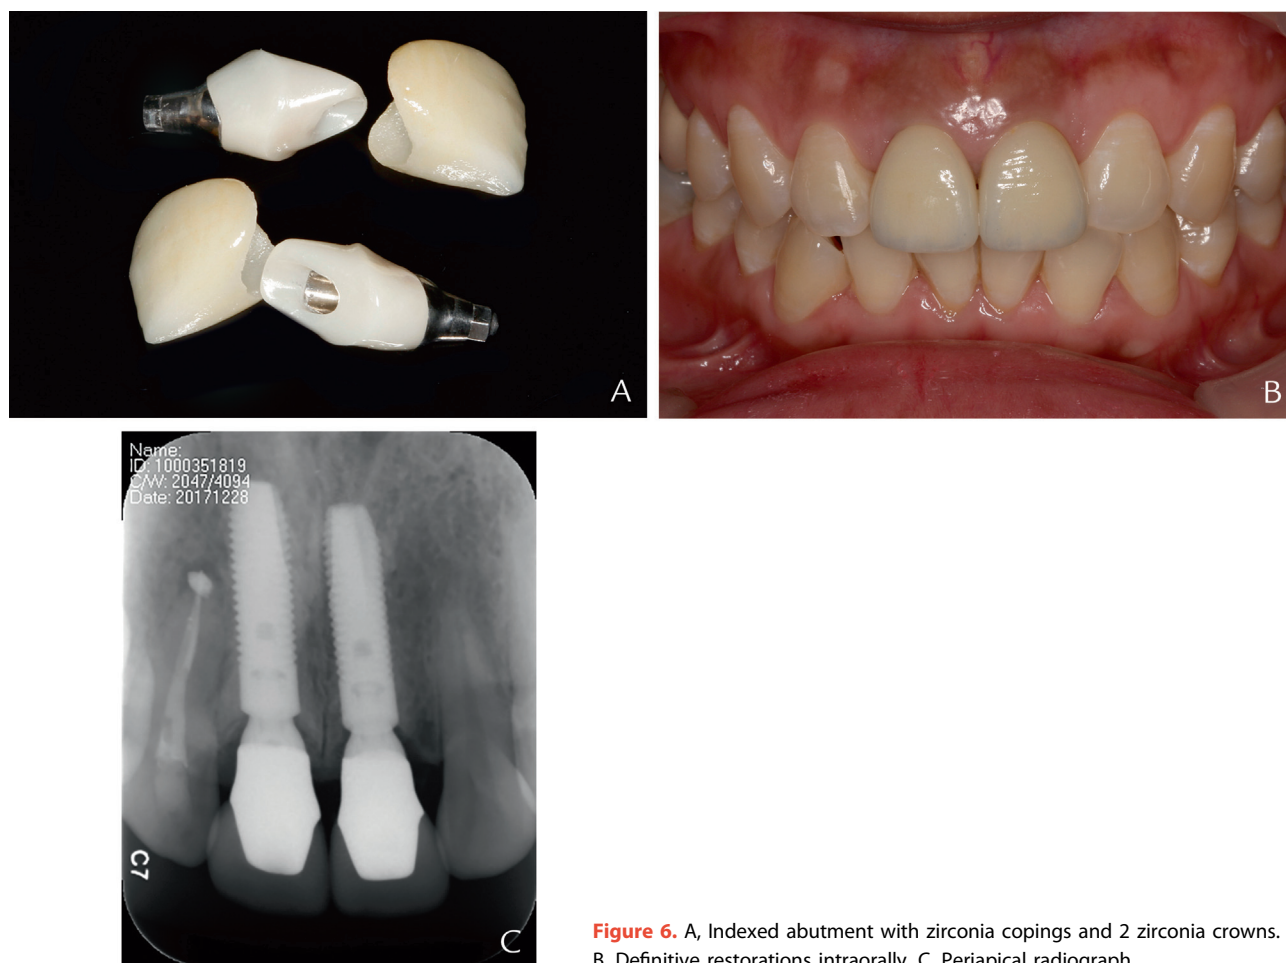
A, Indexed abutment with zirconia copings and 2 zirconia crowns. B, Definitive restorations intraorally. C, Periapical radiograph.
